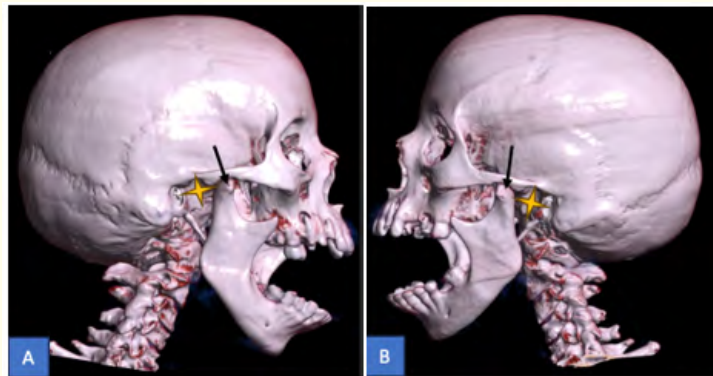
3D CT scan of the facial massif showing anterior displacement of the condyle (black arrow) out of the mandibular fossa (yellow star) on both the right (A) and left side (B).
